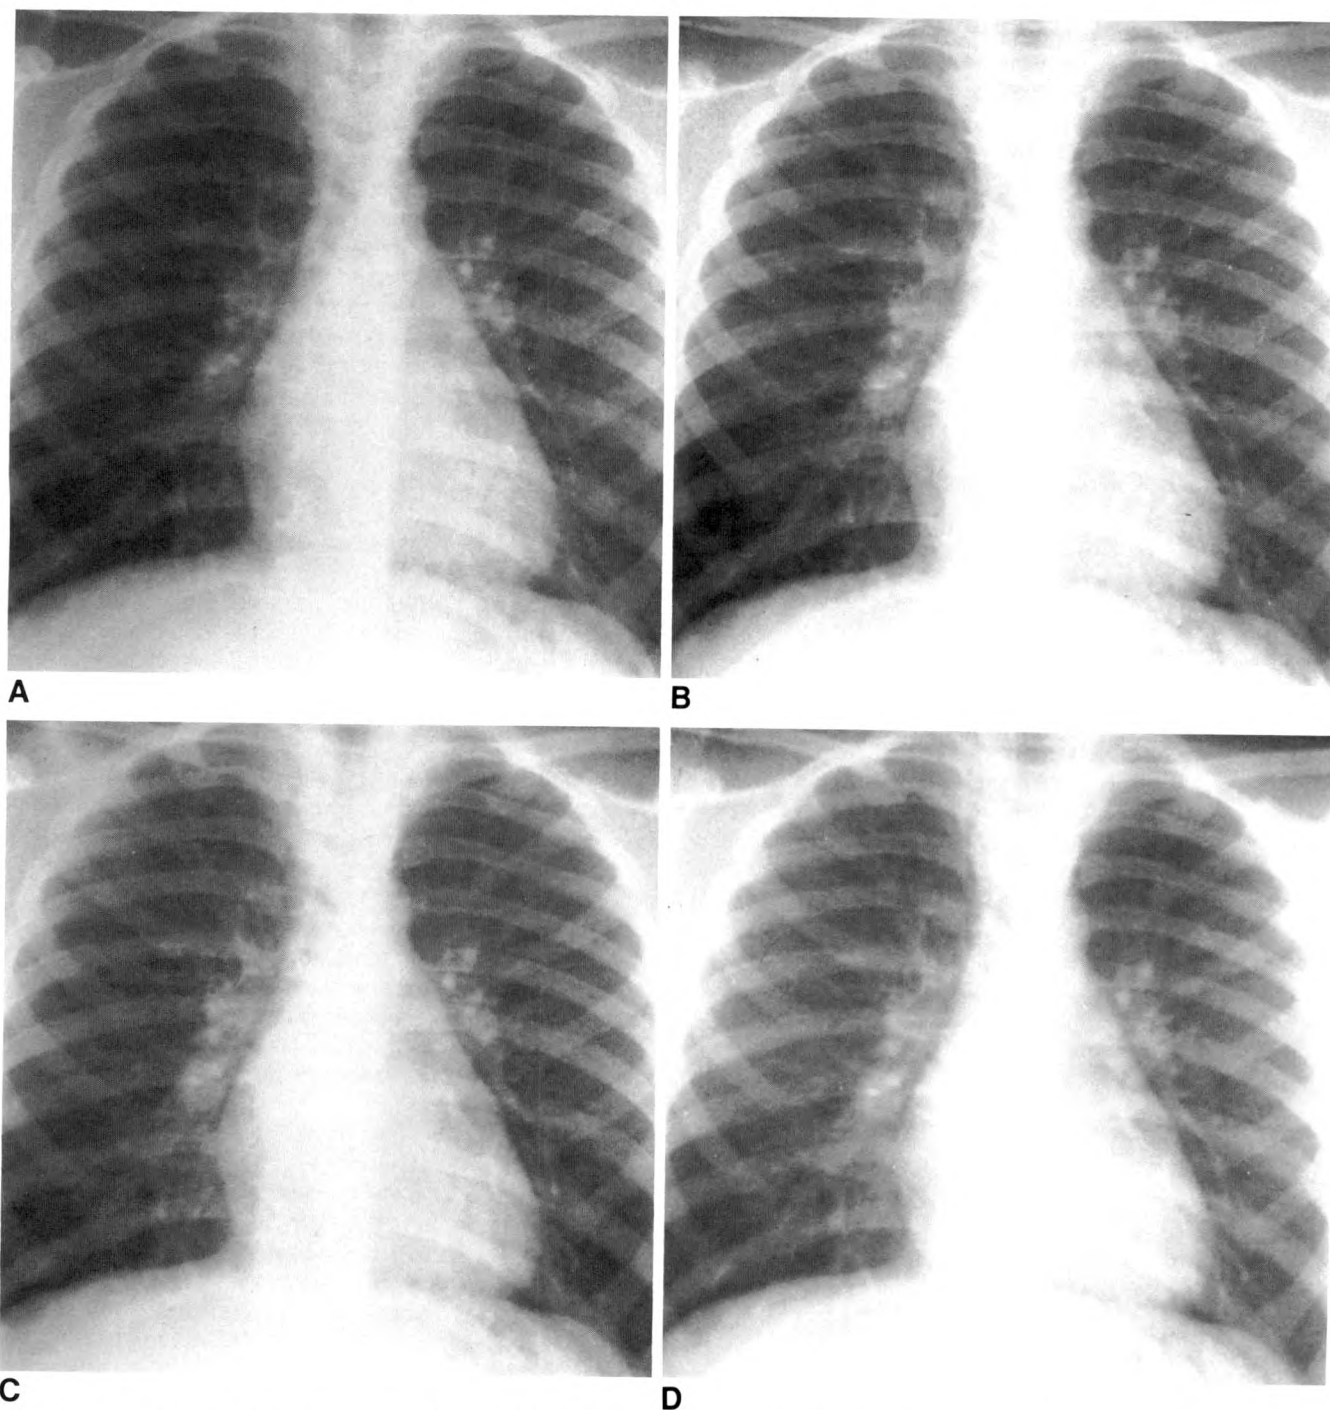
Chest radiographs showing images at four resolutions for one case in the study. A, 5 lp/mm. B, 2.5 lp/mm. C, 1.25 lp/mm. D, 0.625 lp/mm.
